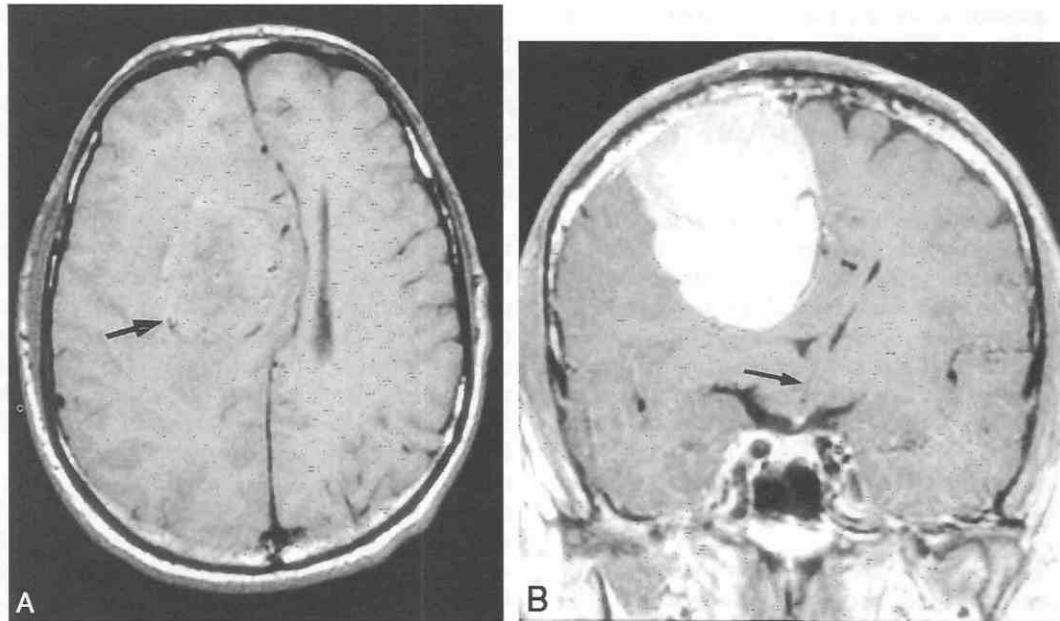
Right high frontal convexity meningioma causing subfascial herniation. A, Axial T1-weighted noncontrast MR image at the level of the cingulate gyri. The right cingulate gyrus is displaced to the left of the midline under the free edge of the falx cerebri by a large lobulated rounded heterogeneous hypo- and isointense parasagittal mass (arrow). Note that the mass is surrounded by focal signal voids representing enlarged vessels on the surface of this extraaxial tumor. A wide band of slight hypointensity surrounding the mass represents vasogenic edema of the peritumoral white and gray matter. B, Coronal T1-weighted postintra-venous gadolinium image through the level of the mid third ventricle demonstrates marked downward and medial displacement of the right side of the corpus callosum and the frontal horn of the right lateral ventricle. The third ventricle (arrow) is bent and displaced across the midline by this large homogeneously contrast enhancing dural based tumor.
